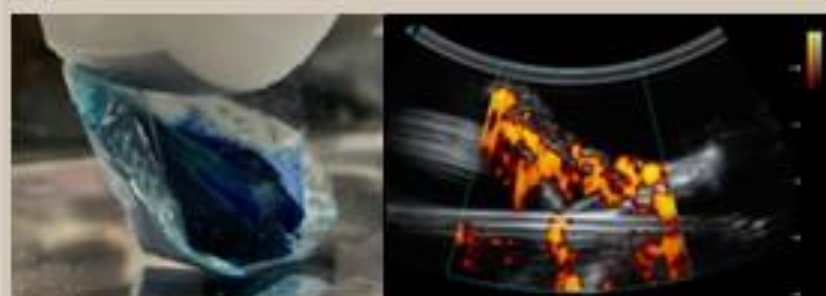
Photo and power Doppler imaging of PLA film pocket
